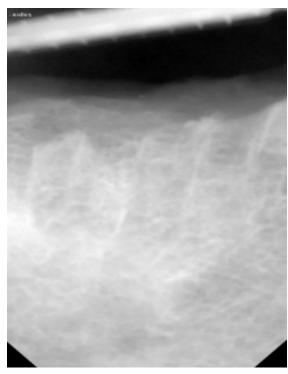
Radiographical examination after 6 months
